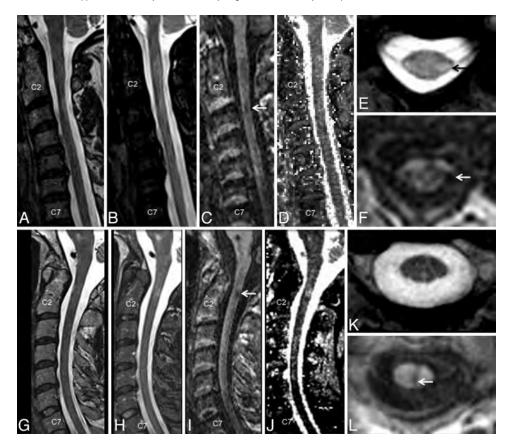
A comparison of imaging techniques for visualization of cervical cord lesions in a 45-year-old woman (A–F) and a 43-year-old man (G–L), both with relapsing-remitting MS. T1-weighted MPRAGE (C and I) performed better than routine clinical T2-weighted FSE (A and G), STIR (B and H), and quantitative T1 maps of the cervical cord (D and J), generated by use of a multiple flip angle gradient-echo sequence. The lesions were also visible on axially reformatted T1-MPRAGE images (F and L) and in these cases were also well visualized on axial T2*-GRE (E and K).
